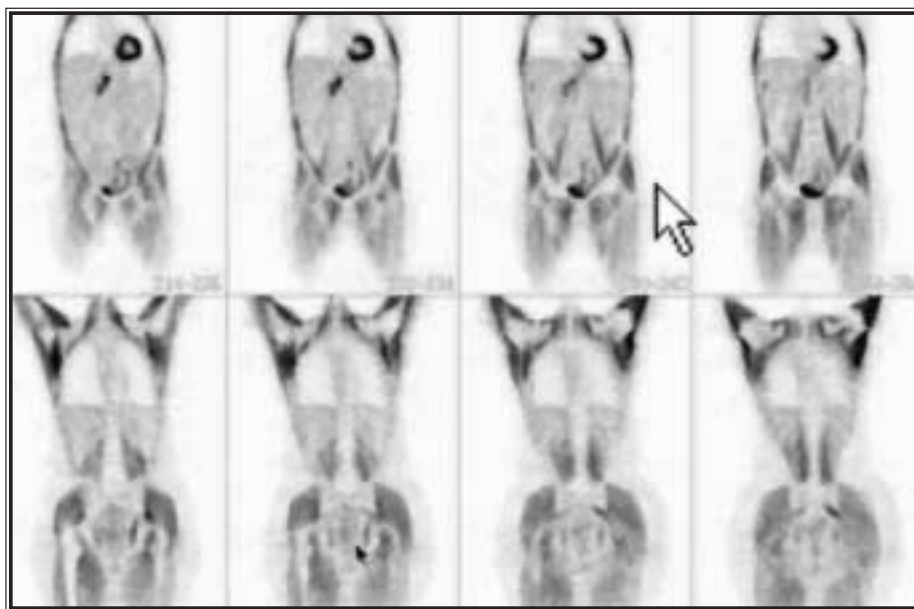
Patient who had exercised vigorously with body-building equipment 24 hours before his PET study. He had also taken a glucose-containing drink a few hours prior to the test. Vigorous exercise should be avoided for at least 24 hours before an FDG-PET scan.
